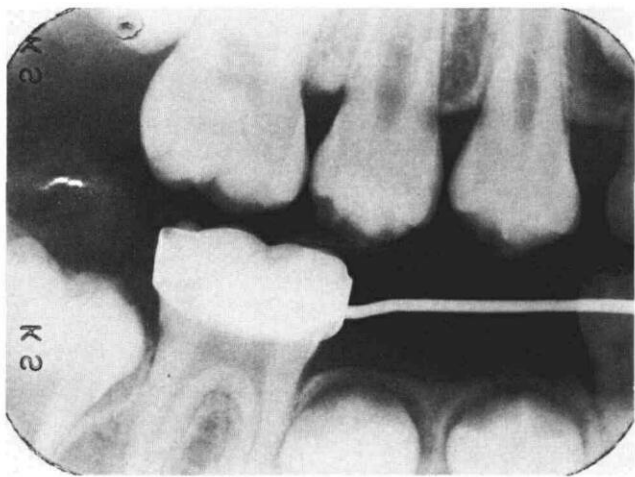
Radiographic survey of patient 2 and a half years post-treatment showing absence of bone destruction around the permanent dentition.
